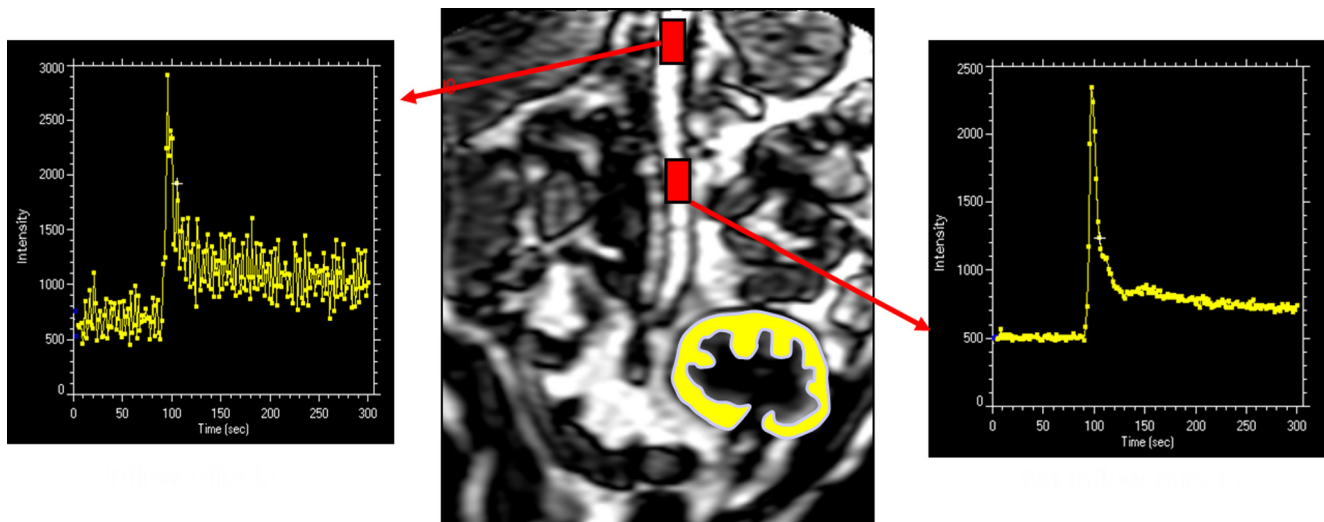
When an arterial input function (AIF) is used with MRI, the ROI has to be placed above renal arteries for native kidneys and on the lower aorta for transplanted kidneys. If positioned too high into the volume, it can be hampered by inflow artifacts.
